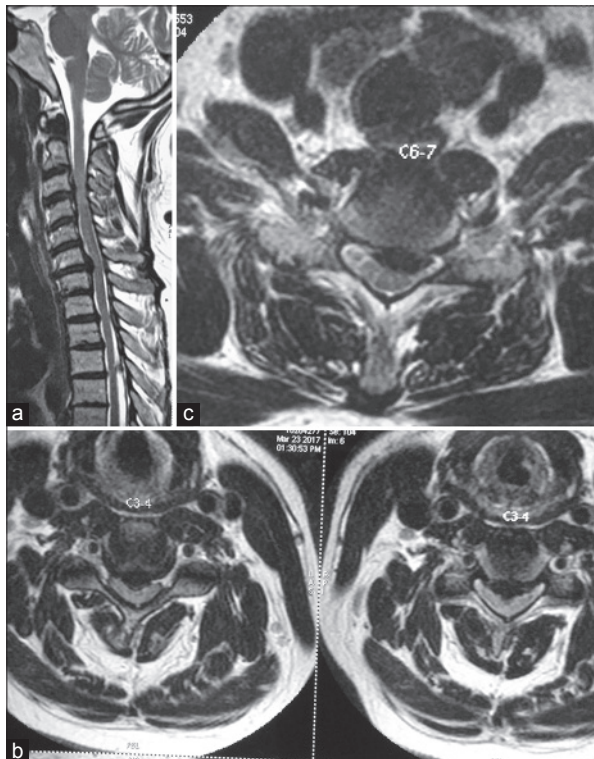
(a) MRI sagittal image of the cervical spine showing degenerated and prolapsed discs at the C3-4 and C6-7 levels. (b) MRI axial image at the C3-4 level showing disc prolapse with cord compression. (c) MRI axial image at the C6-7 vertebral level showing disc prolapse and cord compression
